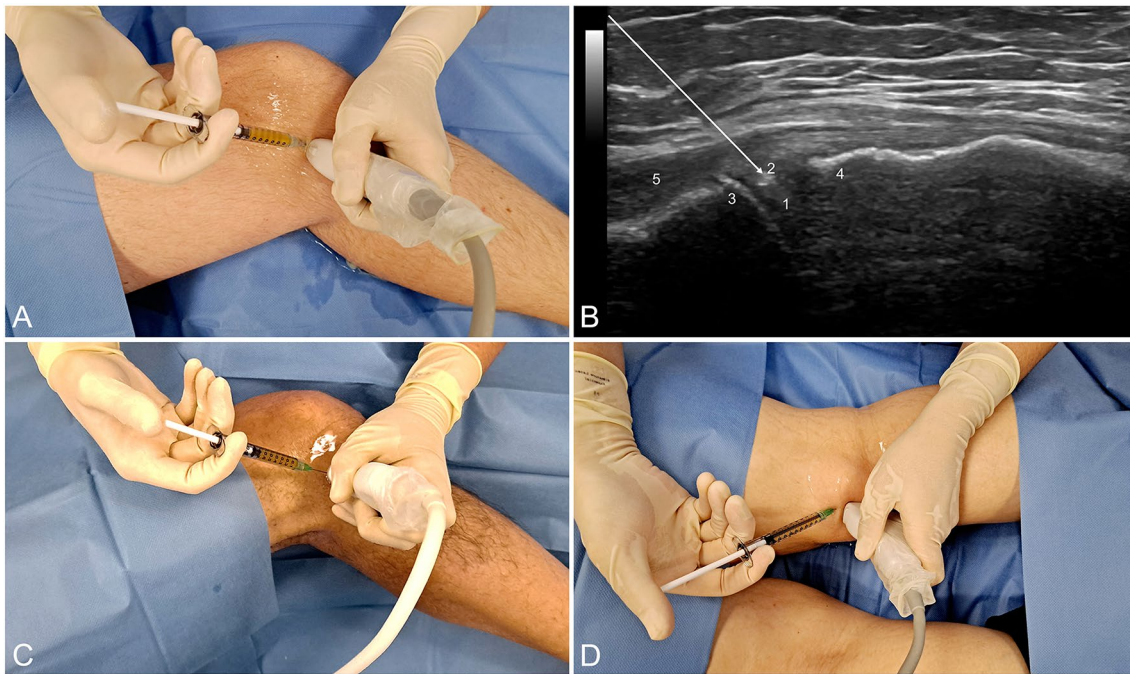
When the injury occurs in the medial meniscus (left knee) (A), the patient is placed in the supine decubitus position with the knee slightly in flexion. Under ultrasound guidance (B), the meniscus is located (1) in order to infiltrate the meniscal wall, with the PRP showing a hyperechoic signal (2). The femoral condyle (3), the tibial
